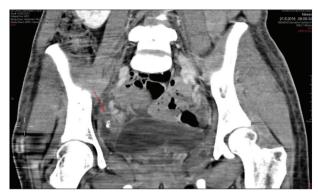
Computed tomography scan of the patient's pelvis
